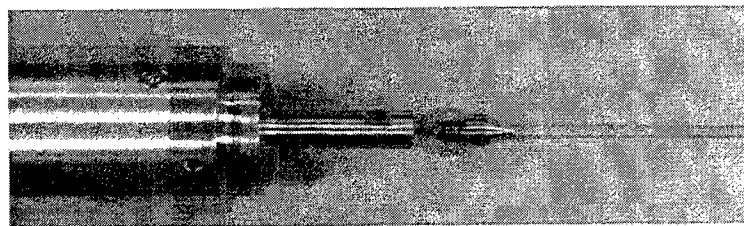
Ultrasound transducer and opto-acoustic waveguide with fiber coupler
